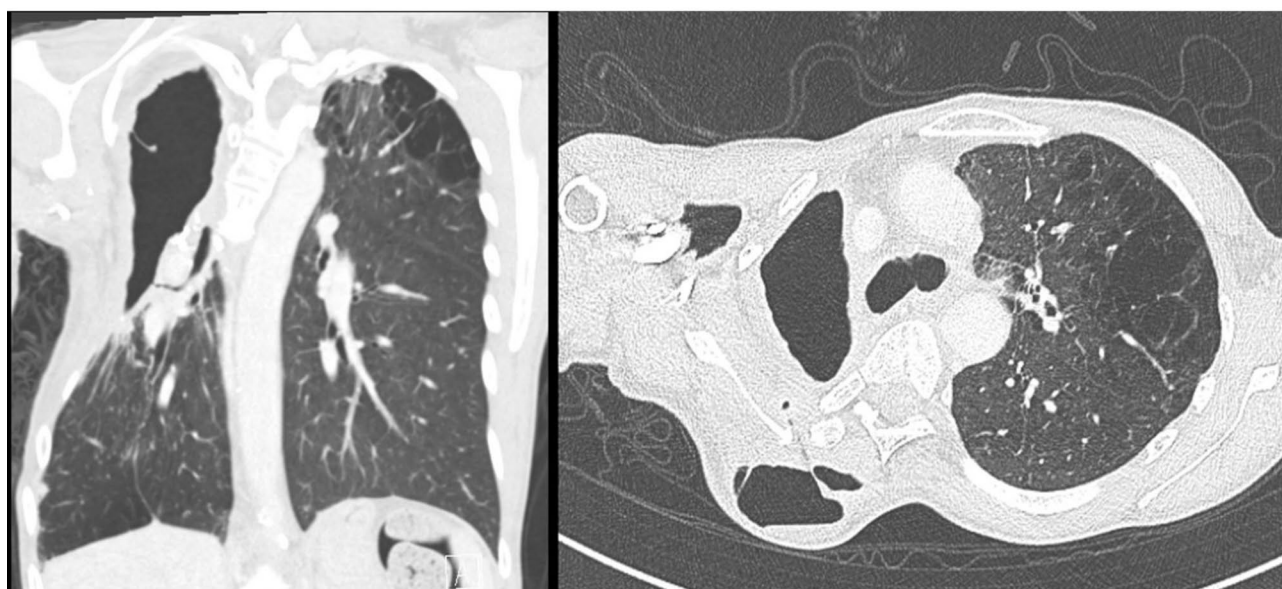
CT chest with contrast: Coronal and transverse views of right upper hemithorax with thick-walled cavity representing a chronic pleural collection with communication to a 6.6 x 3.5 cm chest wall gas-fluid collection resembling empyema necessitans
